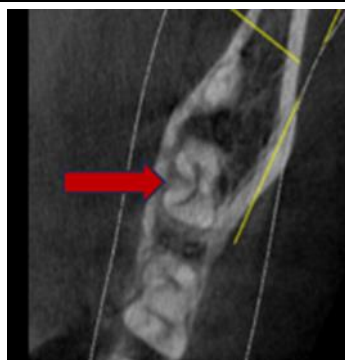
CBCT evaluation – cross section view (middle third)
